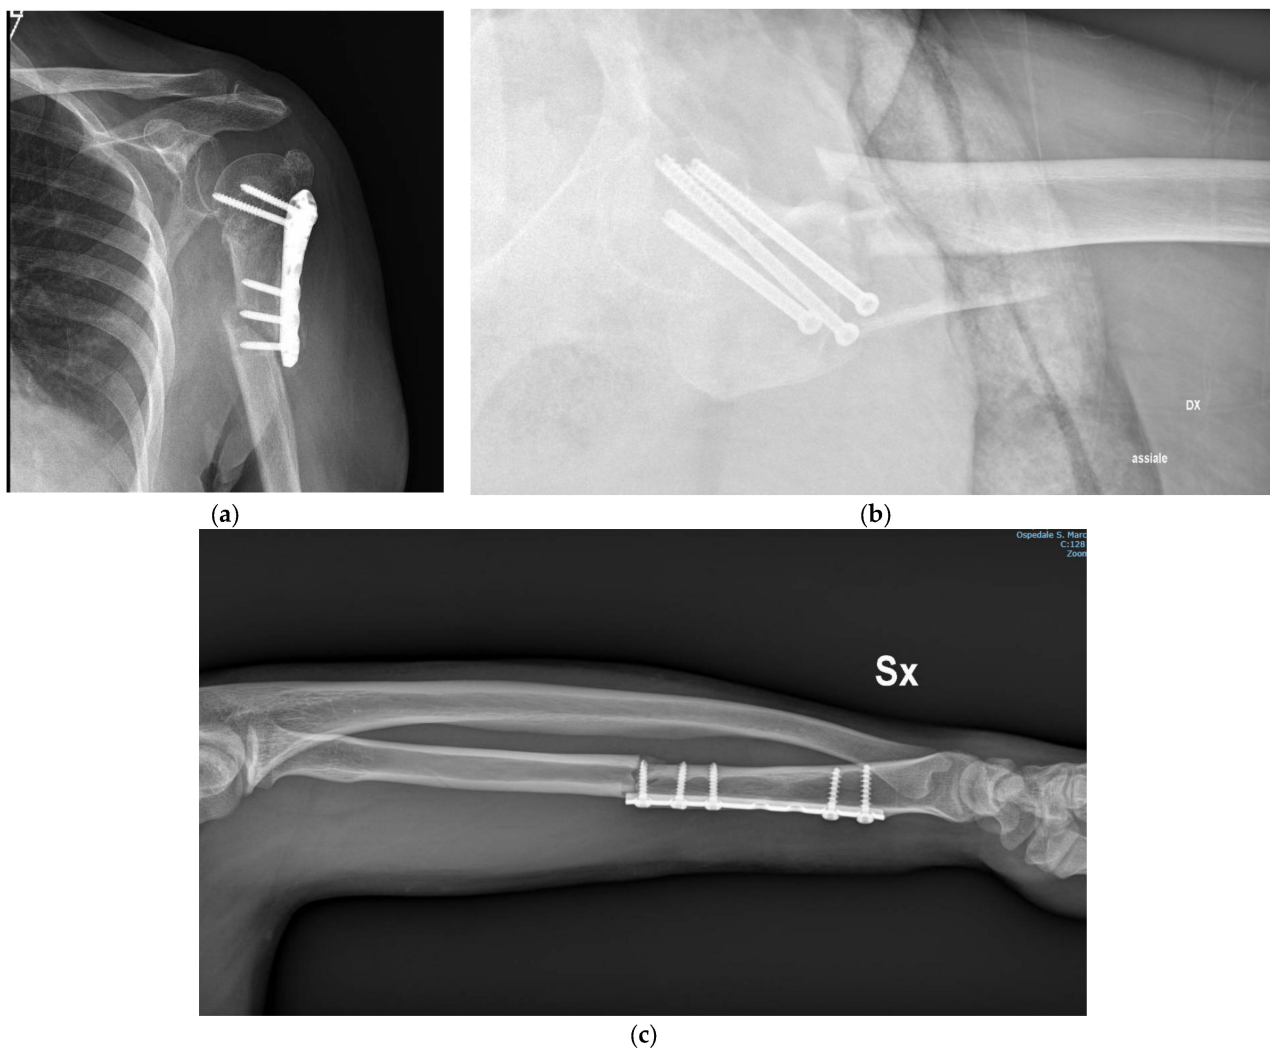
Some examples of peri-implant fractures and their corresponding codes. (a) The X-ray shows a humerus (“1”) previously treated with plate and screws (α); the hardware is placed in the proximal third of the humerus (I), and the fracture is in correspondence with the distal part of the hardware (B3). The referring code is 1 α IB3. (b) The X-ray shows a femur (“3”) previously treated with screws (β); the hardware is placed in the proximal third of the femur (I), and the fracture is distal to the hardware (C). The referring code is 3 β IC. (c) The X-ray shows a radius (“2R”) previously treated with plate and screws (α); the hardware is placed between the middle third and distal third of the radius (V), and the fracture is in correspondence with the proximal aspect of the hardware (B1). The referring code is 2R α VB1.
